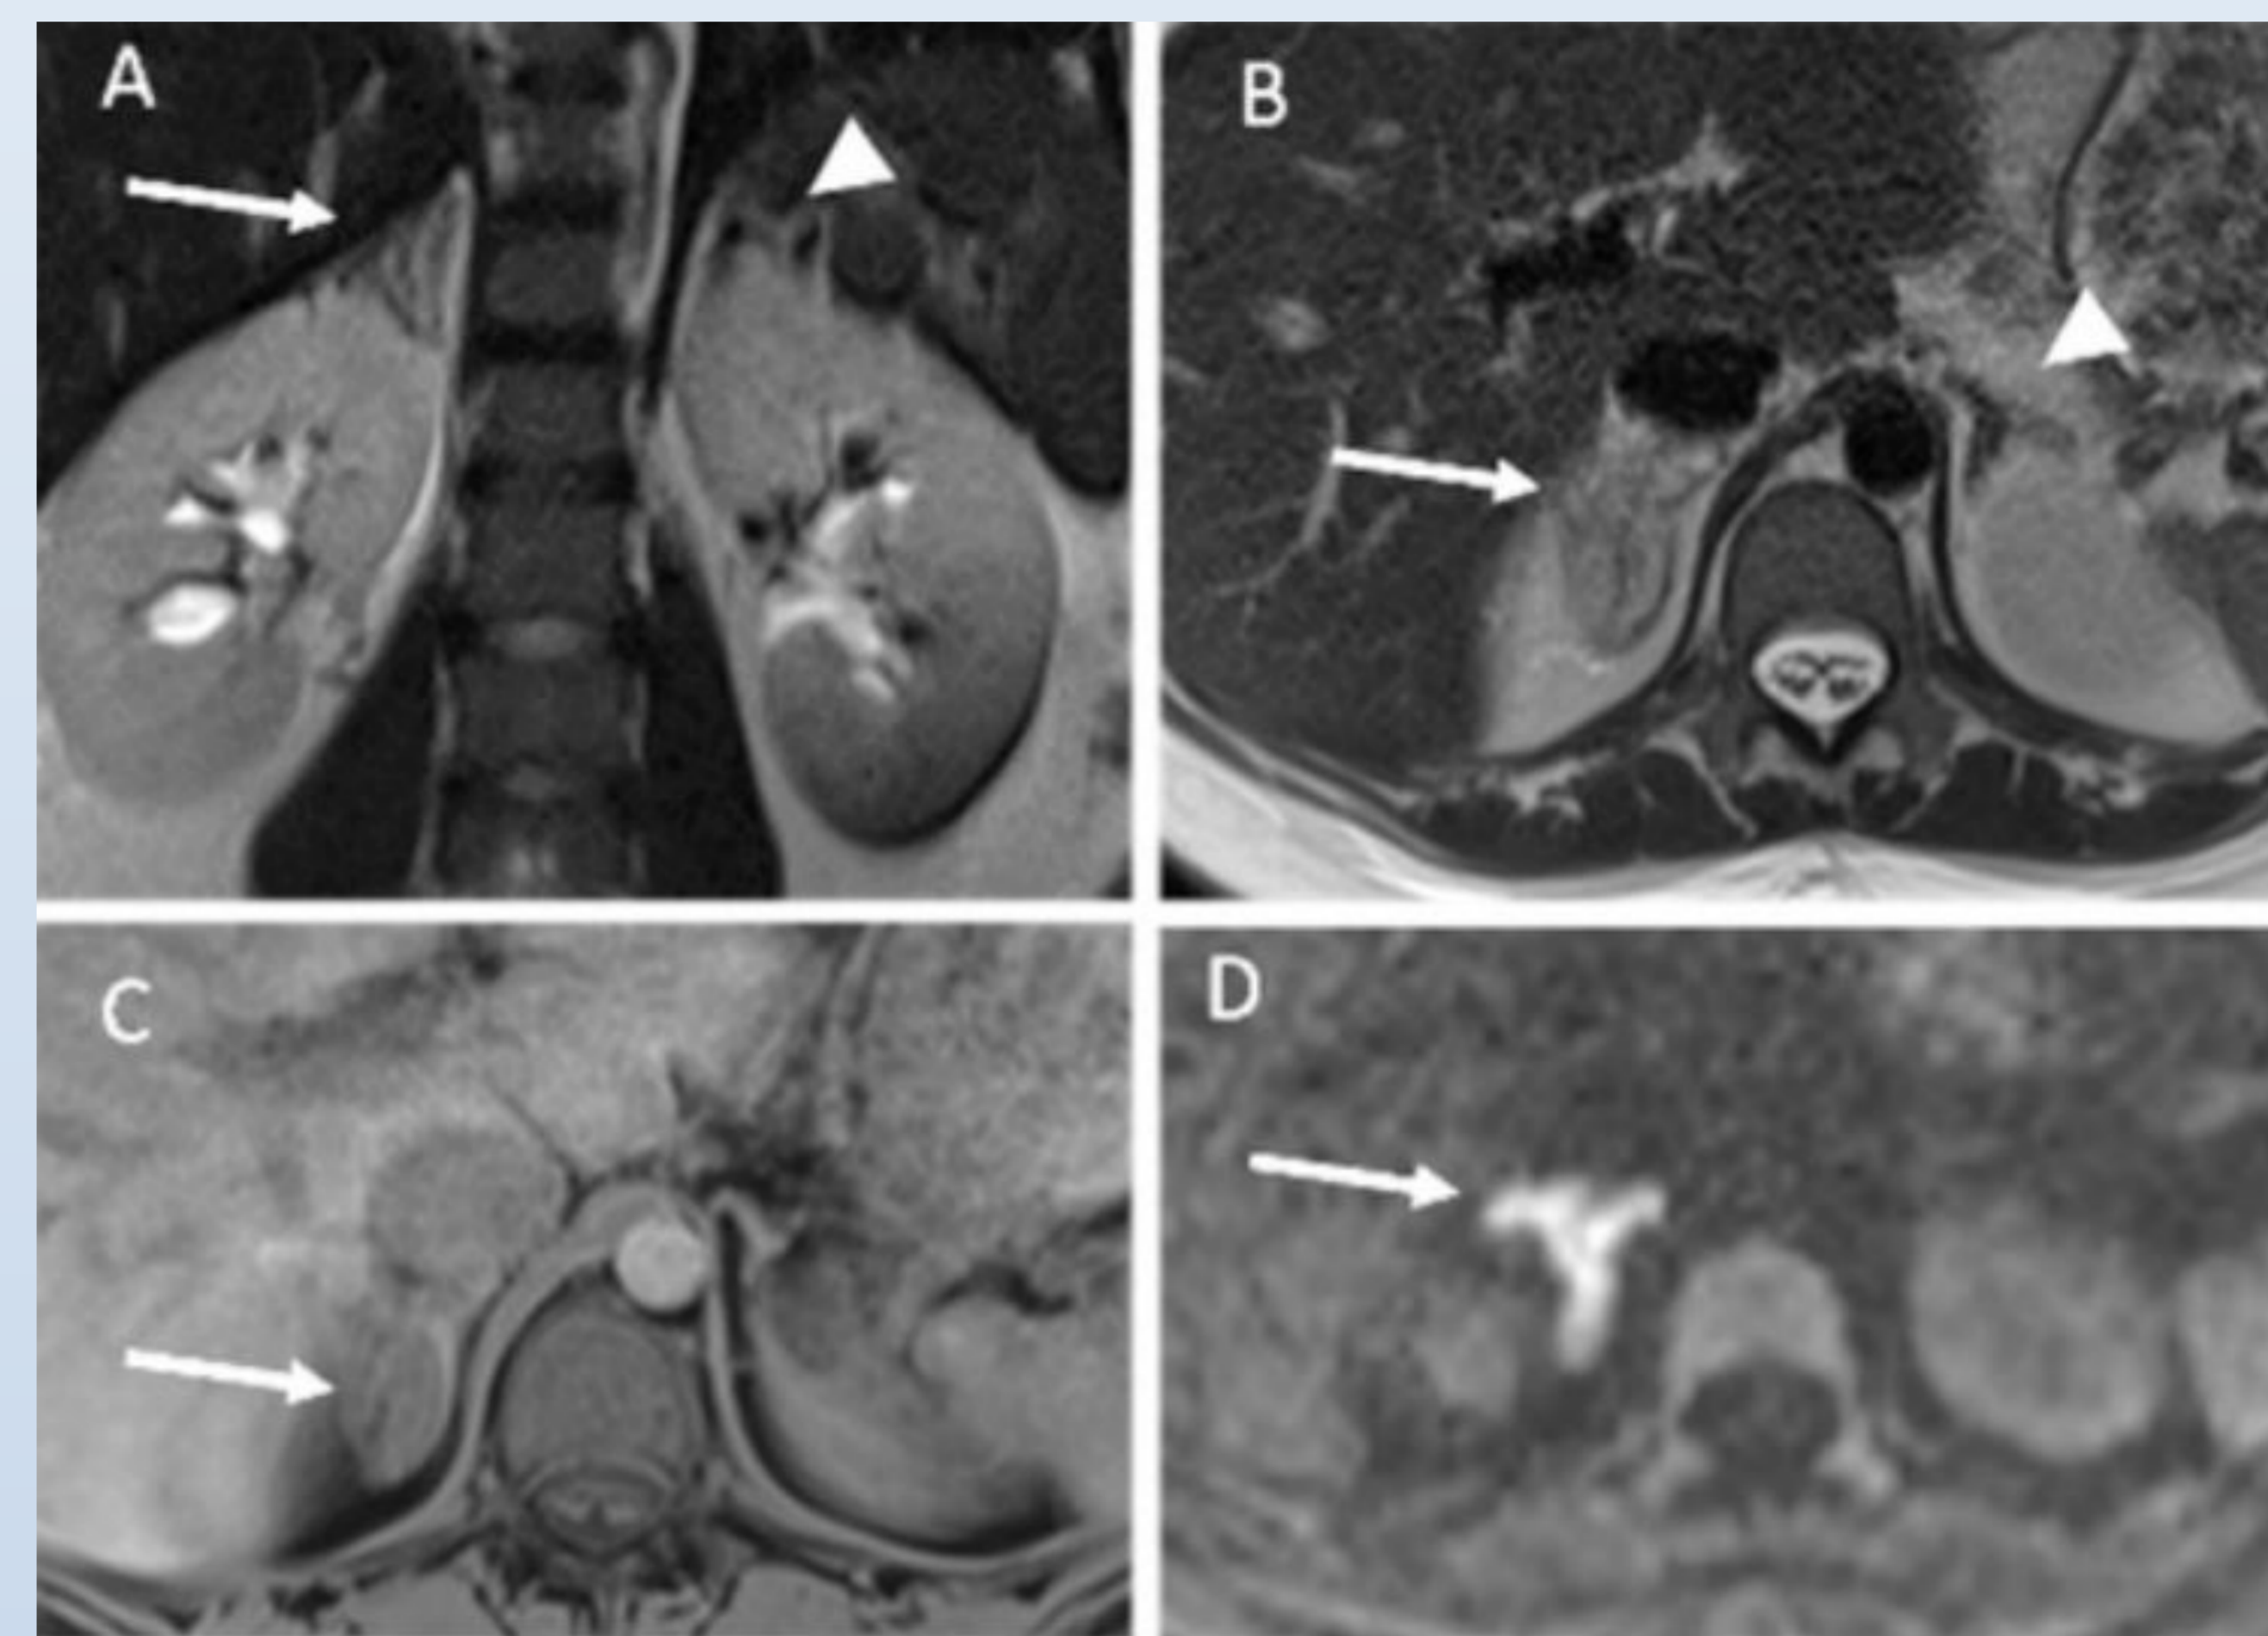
MRI findings: (A,B) T2-weighted MR imaging, coronal (A) and axial (B) planes showing oedema of the right adrenal gland (arrow) and adjacent fat. No abnormality of the contralateral gland (arrowhead). (C) Unenhanced axial T1-weighted imaging showing no hyperintensity of the adrenal gland (arrow). (D) Diffusion-weighted MR imaging (b800) showing restricted diffusion of the adrenal gland (arrow).
